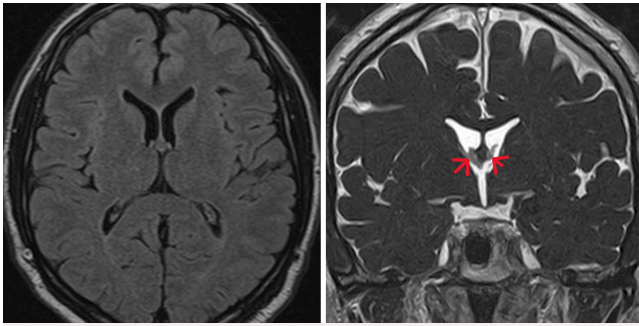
First MR image (left) documenting regression of the CC. The FLAIR image (right) clearly does not show the hyperintense structure that had been followed for 4 years. A signal (red arrows) is visible, likely representing remnants of the cyst wall attached to the tela choroidea and choroid plexus, suggesting the theoretical possibility of a spontaneous rupture. However, it could also represent parts of the choroid plexus.
